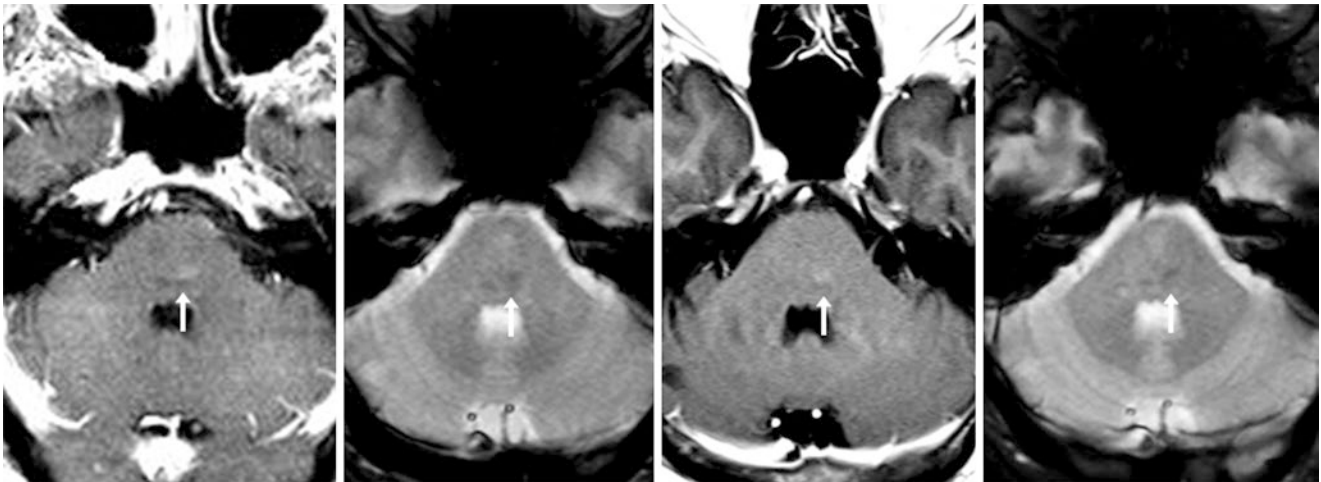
A 43 year old was examined for altered mentation. There was faint enhancement of a pontine BCT (arrows) on a 1.5T MRI with postcontrast SE T1WI (left), and a faint dark signal on GE T2*WI (left
